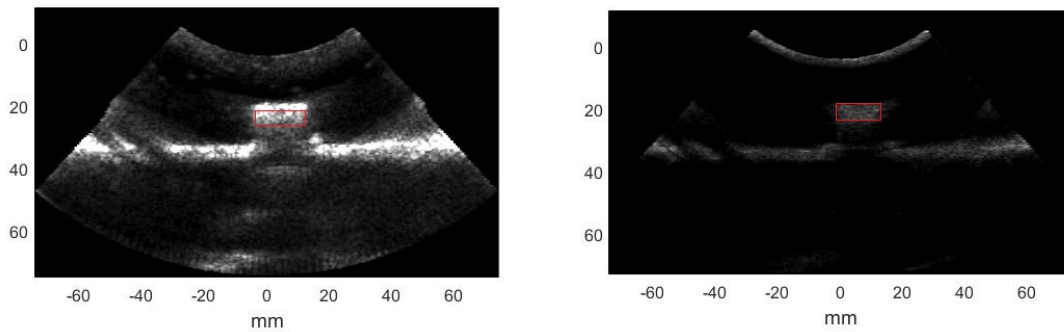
The B-mode Ultrasound Images from the Fundamental Backscatter (left) and the Second Harmonics (right). The Selected Region is the Region of Interest.*
